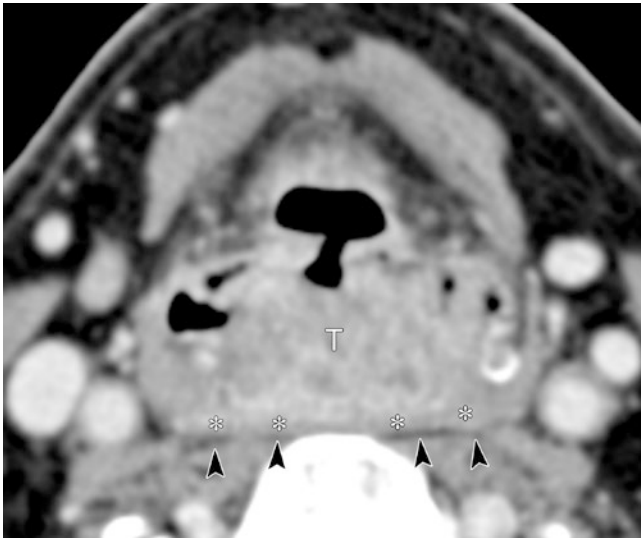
Posterior wall hypopharyngeal carcinoma without retropharyngeal space infiltration. Axial contrast-enhanced CT shows the tumor (T) at the center of the hypopharynx posterior wall. The lesion appears to be limited to the posterior wall of the hypopharynx, not extending to the side wall. In the posterior direction, the inferior pharyngeal constrictor muscle (asterisk) and fat layer of the retropharyngeal space (black arrowheads) are intact
